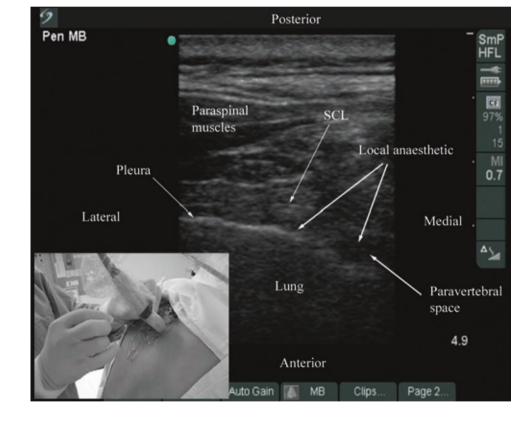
Ultrasound-guided TPVB using a transverse scan in which the block needle is inserted in the short axis of the ultrasound plane (Technique 1). (Note the widening of the paravertebral space and anterior displacement of the pleura by the local anesthetic on the transverse sonogram. The local anesthetic is also seen to spread to the posterior intercostal space laterally. The picture in the inset shows how the transducer is oriented and the direction in which the needle is inserted. SCL superior costotransverse ligament)
